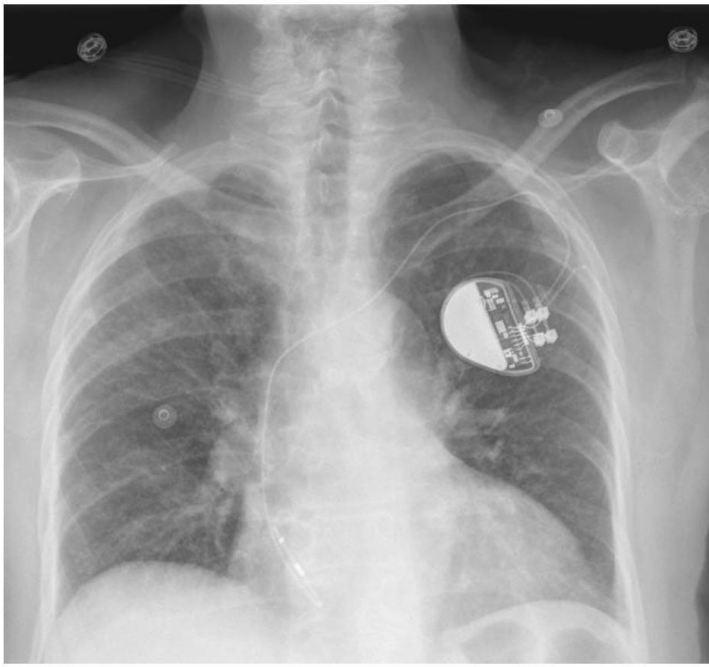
Admission chest x-ray showing transected ventricular lead and intact atrial lead
